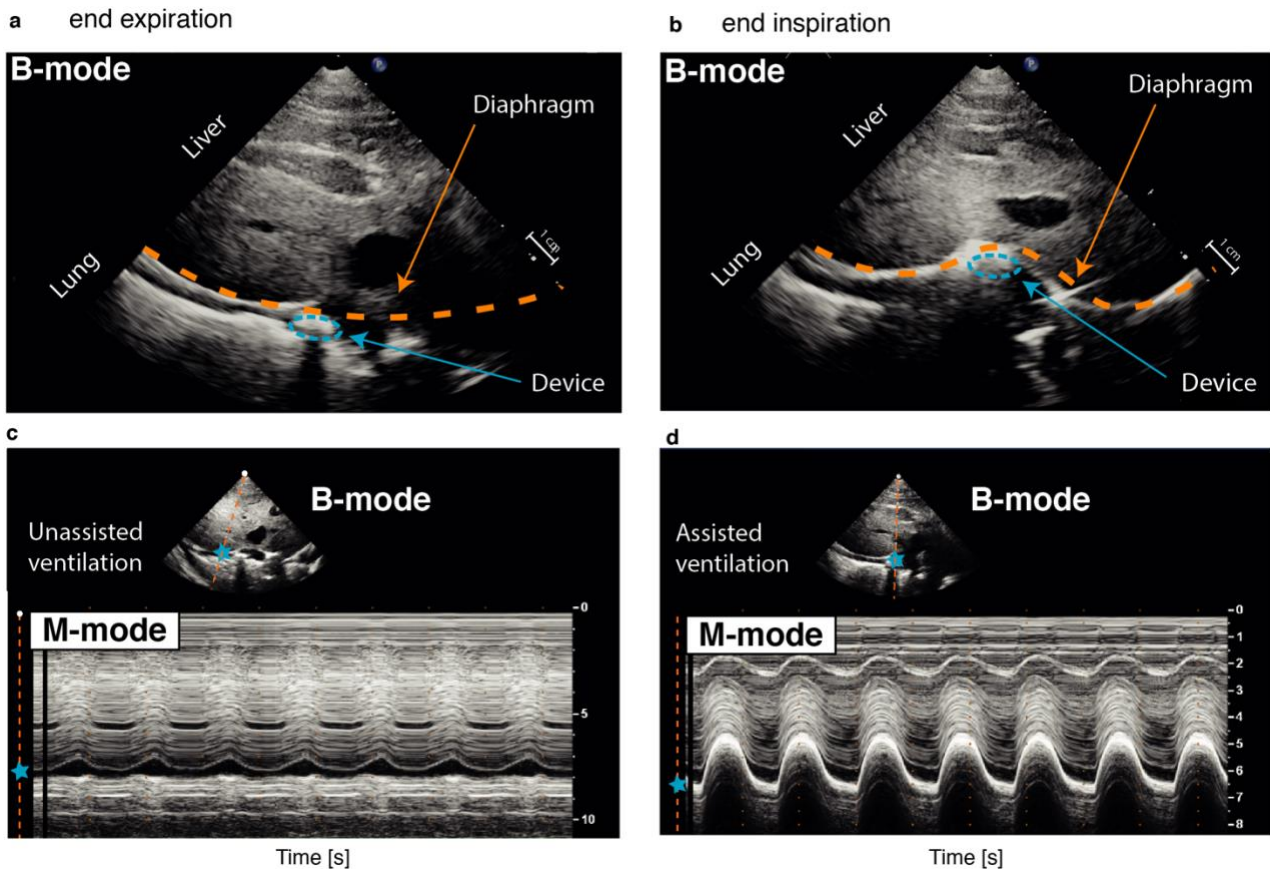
Ultrasound imaging of the diaphragm and its associated displacement with and without assisted ventilation. (a-b): Two-dimensional view (B-mode) of the diaphragm at (a) the end of expiration (device not pressurized, muscle relaxed) and (b) at the end of inspiration (device pressurized, muscle contracted). (c-d) M-mode evaluation of diaphragm motion during (c) unassisted ventilation, and (d) assisted ventilation (20 psi). For all images, the probe was positioned in the right subcostal space, pointing toward the cranial direction. Orange dashed line: diaphragm, blue dashed ellipse: actuator cross-section, blue star: spatial position of the diaphragm.
